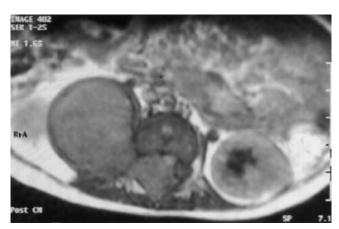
MRI of large-stage 2A paraspinal neuroblastoma with epidural extension ("dumbbell") causing paraplegia in infant. Paraparesis was still present 34 mo after partial tumor resection.
